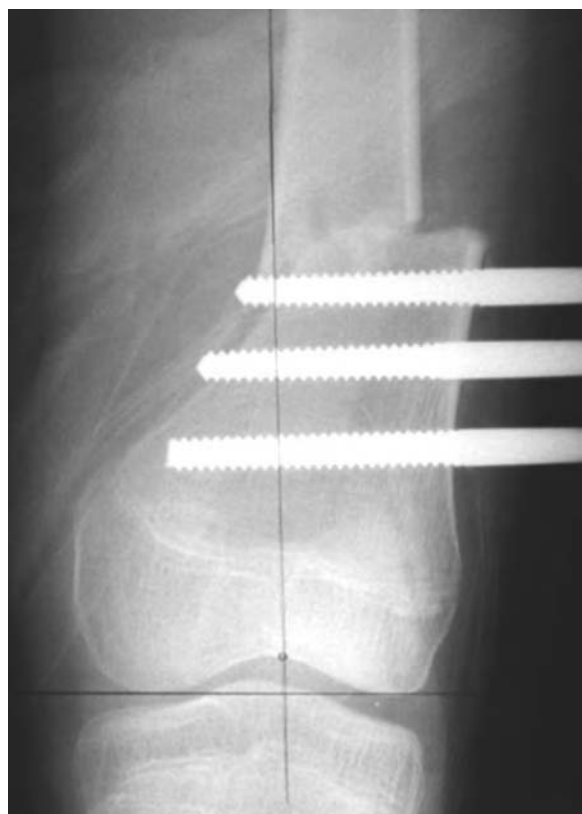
Radiograph shows acute valgus correction performed at the osteotomy site for lengthening.
